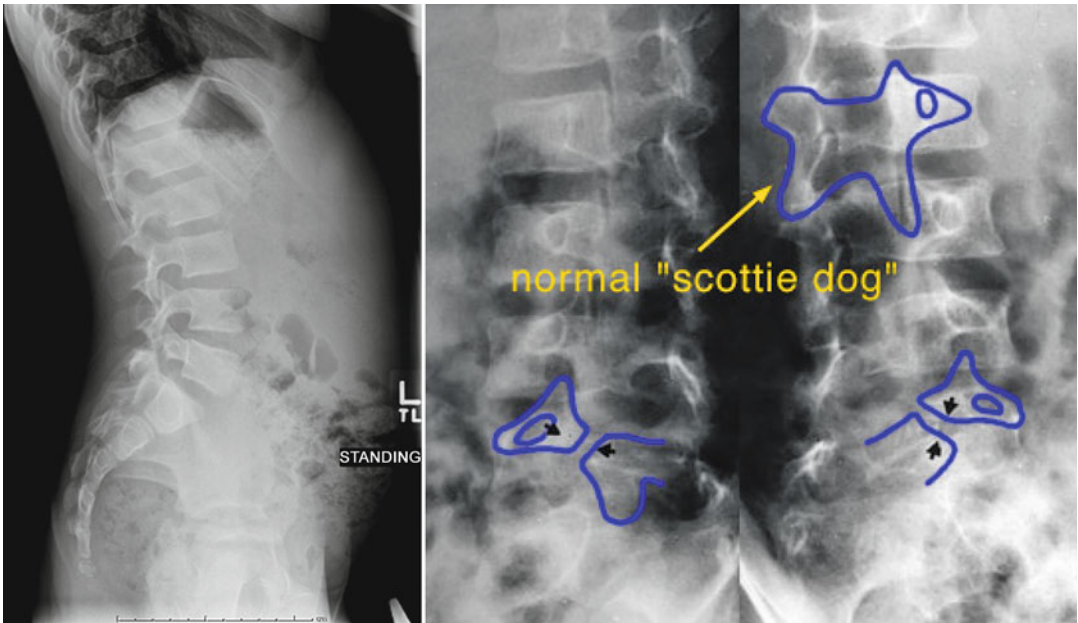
Occasionally, bilateral spondylolyses can be visualized on lateral projection x-rays as seen in this figure. However, more commonly they are best seen on
